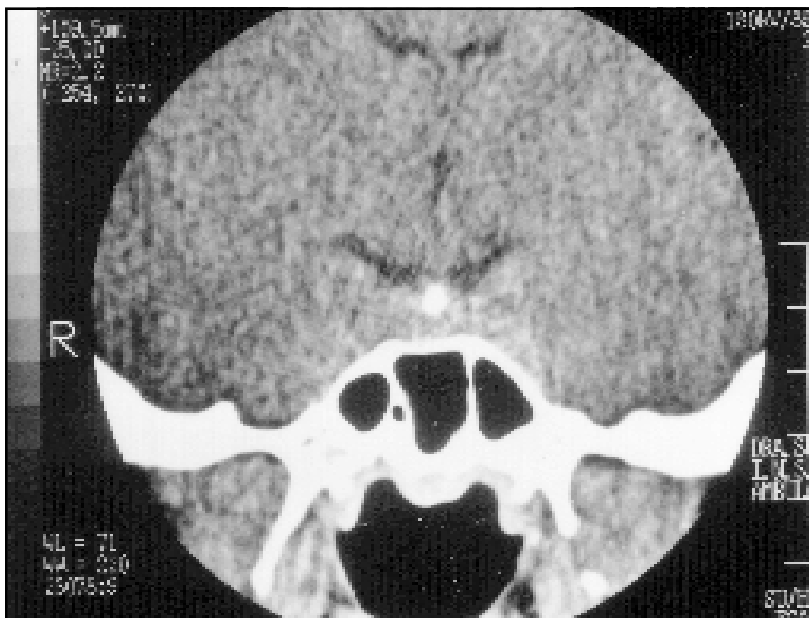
CT scan of the sellar region showing calcification of the pituitary stalk.
